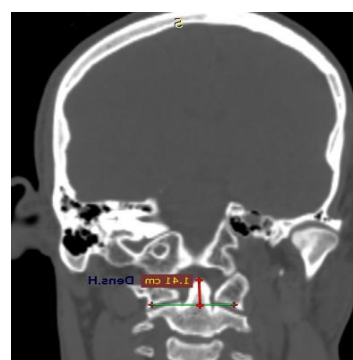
CT scan coronal section in the head and neck show the measurement of dens height.
